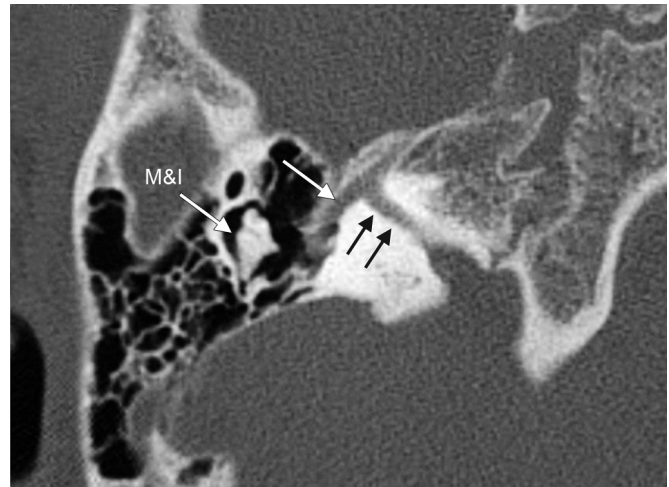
Axial CT image of a patient with labyrinthine aplasia demonstrates a hypoplastic otic capsule with complete absence of the inner ear structures. The facial canal with the labyrinthine (black arrows) and tympanic (white arrow) segments is well visualized.
